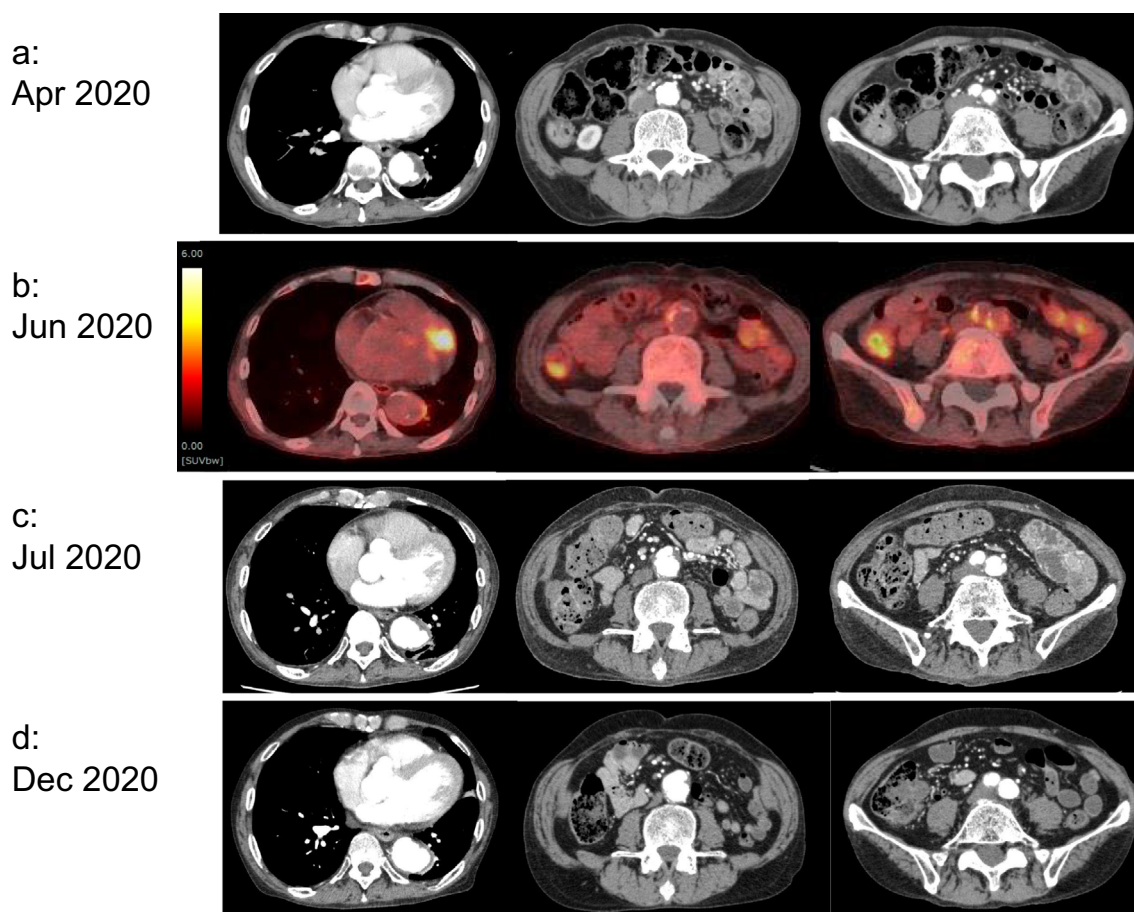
Contrast-enhanced computed tomography (CE-CT) and positron emission tomography (PET)/CT using ^{18}F -fluorodeoxyglucose (FDG) throughout the clinical course. (a) A non-communicating aortic dissection with an ulcer-like projection in the descending thoracic aorta was suspected based on the CE-CT findings in April 2020. (b) FDG-PET/CT in June 2020 showed a minimal uptake in the walls of the aorta and the bilateral common iliac arteries. (c) CE-CT in July 2020 revealed an increase in the size of the thoracic descending aorta, infrarenal aorta, and the origins of the bilateral common iliac arteries, and infectious aneurysms were suspected at this time. (d) CE-CT in December 2020, after five months of treatment with antibiotics, showed no further increase in the size of the aneurysms.
